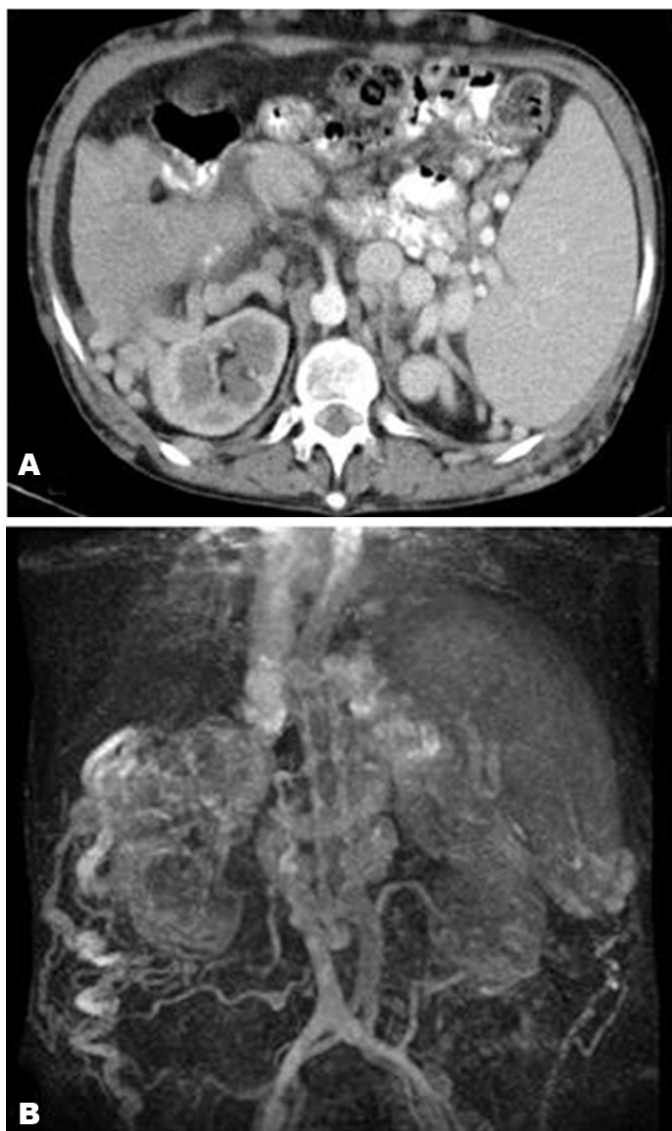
(A, B): Contrast computed tomography scan showing exuberant retrocrural collateral circulation and varices, and abdominal magnetic resonance imaging scan confirming inferior vena cava agenesis.
